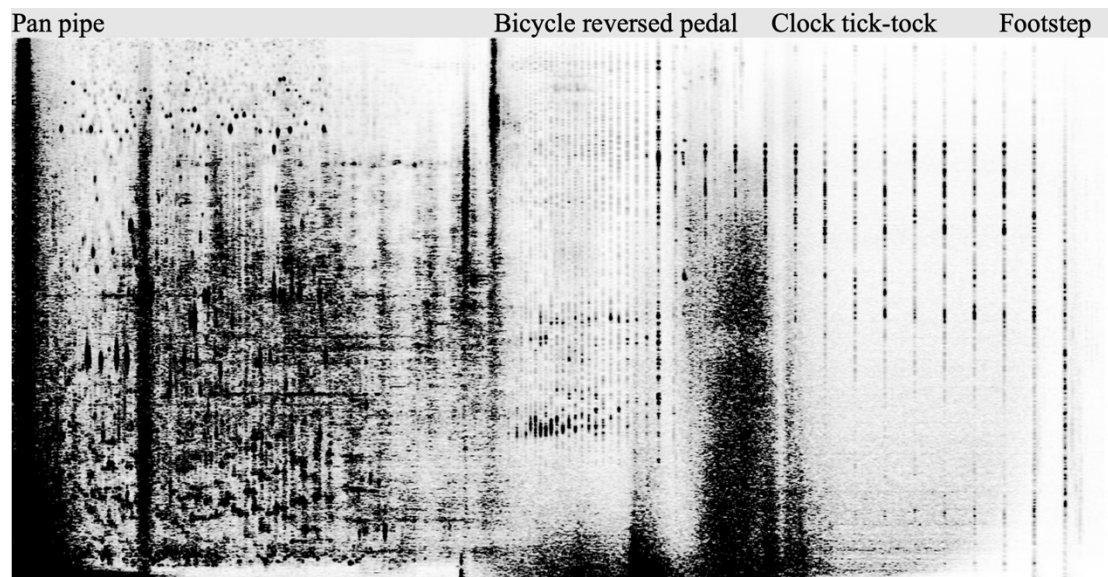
Sonogram extracted from the last section of *AI Phantasy*, a section from 10:26-11:10 minutes.³¹
